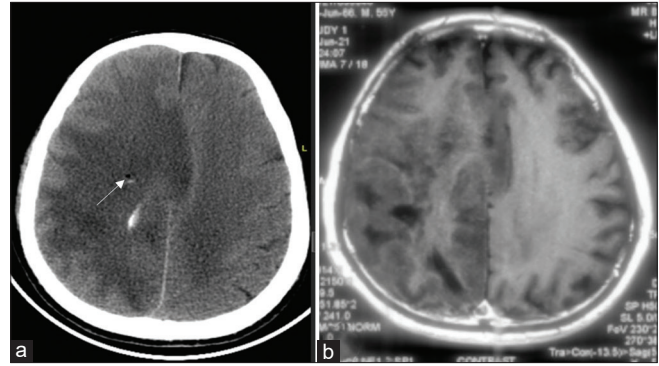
(a) Post procedure plain computed tomography showing midline shift and edema as an indirect evidence at corresponding cuts with a white arrow indicating biopsy site. (b) In an index case of the right diffuse hemispheric glioma preoperative contrast magnetic resonance imaging sequence.
